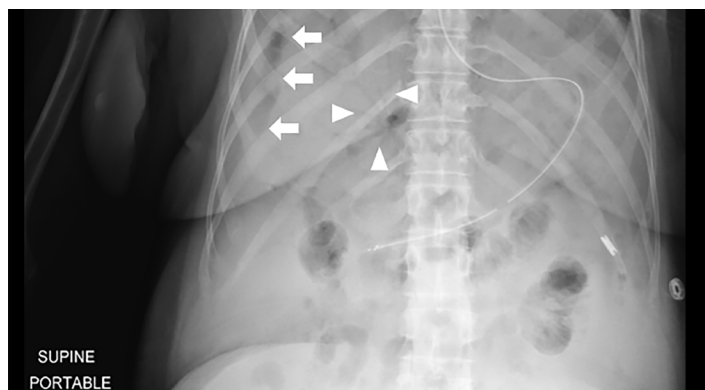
Upright abdominal radiograph revealing free air along the lateral margin of the liver (arrows) and branching gas in the liver (triangles), concerning for portal venous gas.
